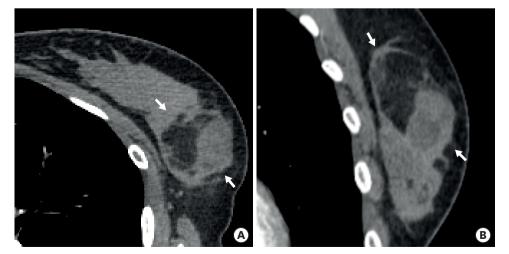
Contrast-enhanced axial (A) and coronal chest computed tomography (B) showed an oval-shaped heterogeneously enhanced mass with a non-enhancing fat component (arrows).
